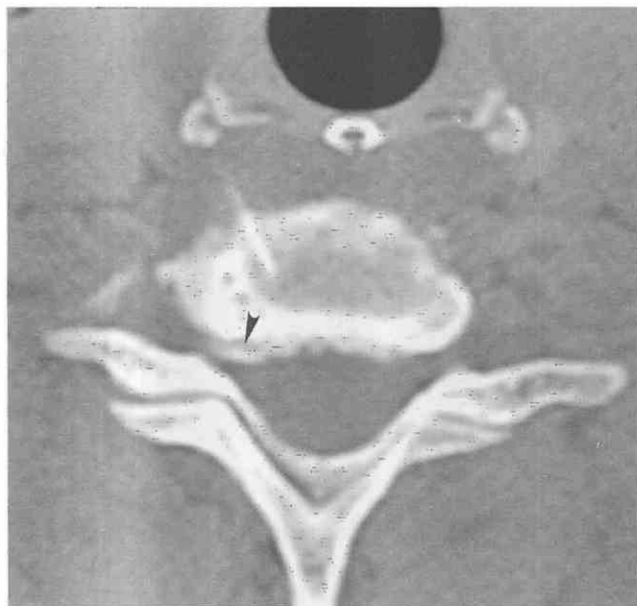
Cervical diskography at the C5-6 level performed with CT guidance using a 25-gauge needle via an anterior-lateral approach. The patient's right arm pain was reproduced exactly on injection of 0.5 mL of iodine contrast medium. After injection, the CT scan also demonstrates a small amount of contrast medium filling a right posterior-lateral disk protrusion (arrowhead).
